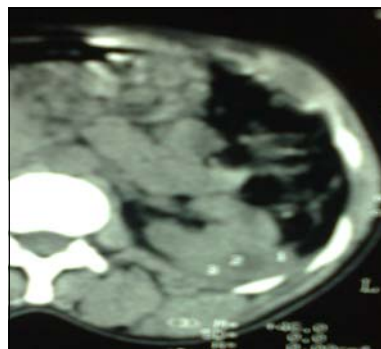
CT pictures of Kidney and Mass Pre Contrast Administration
